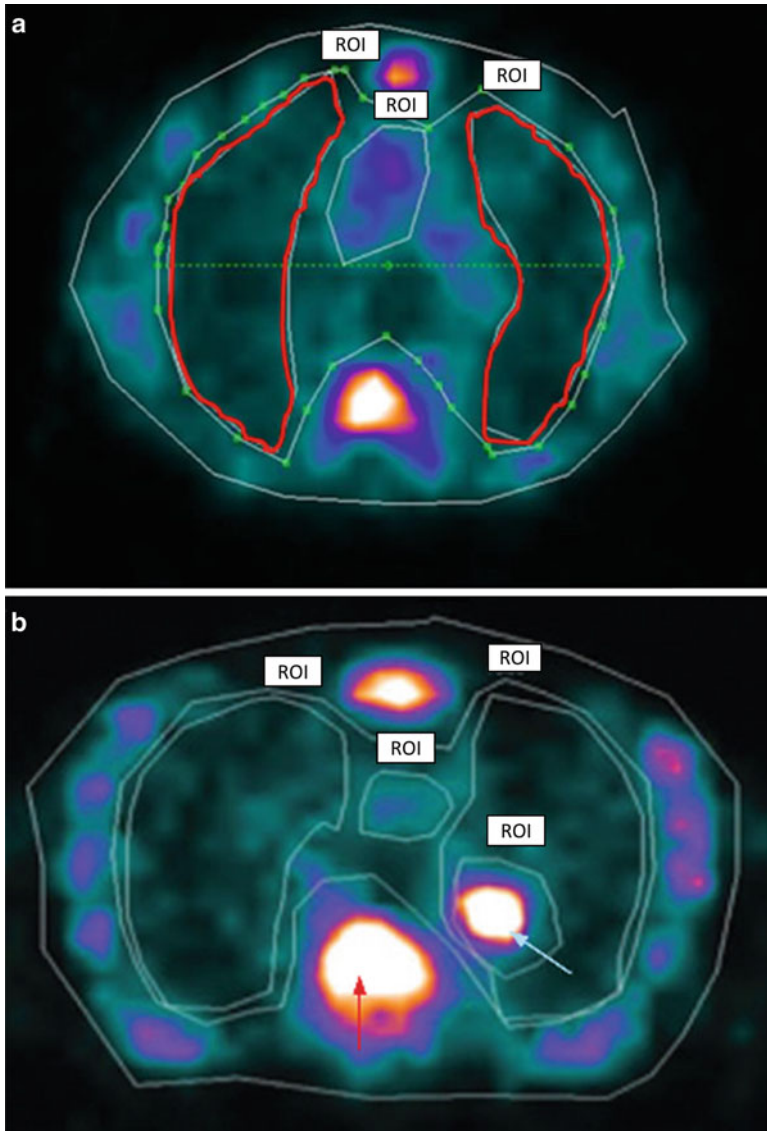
(a) SPECT image demonstrating increased Tc-99m-labelled neutrophil uptake in the lung parenchyma of COPD patients. Regions of interest highlighted over the lungs (*red outline*), heart, and bone marrow (ribs, sternum, and vertebral body) (Ruparelia et al. 2011). (b) SPECT image indicating focal uptake of Tc-99m-labelled neutrophils in the left lower lobe of the lung (*blue arrow*). The *red arrow* indicates physiological uptake in the vertebral bone marrow) (Ruparelia et al. 2009)
